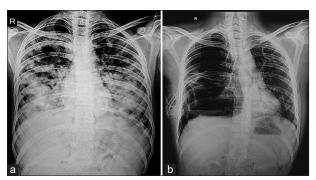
Serial X-ray chest suggestive of healed parenchymal lesions with cyst formation and right sided hydropneumothorax with intercostal drainage tube *in situ*
